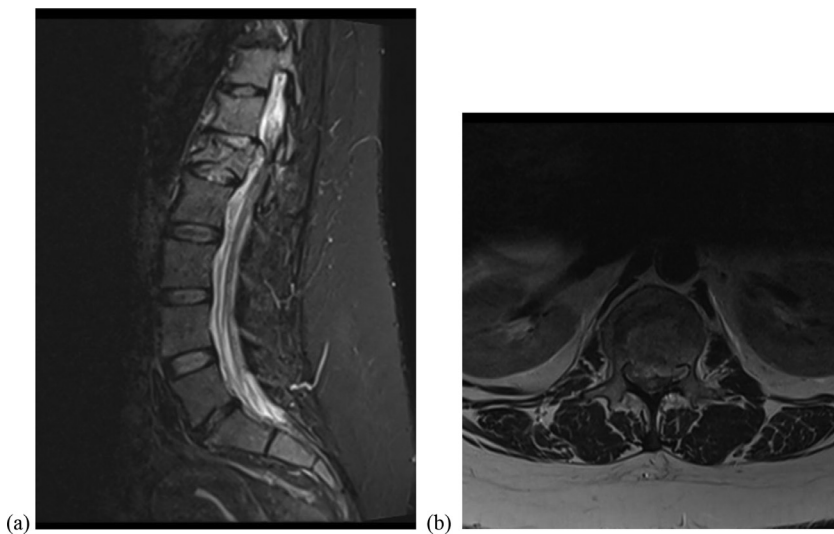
Representative mid-sagittal STIR MRI (a) and T2 sequence MRI (b) of L1 burst fracture demonstrating cord compression.
